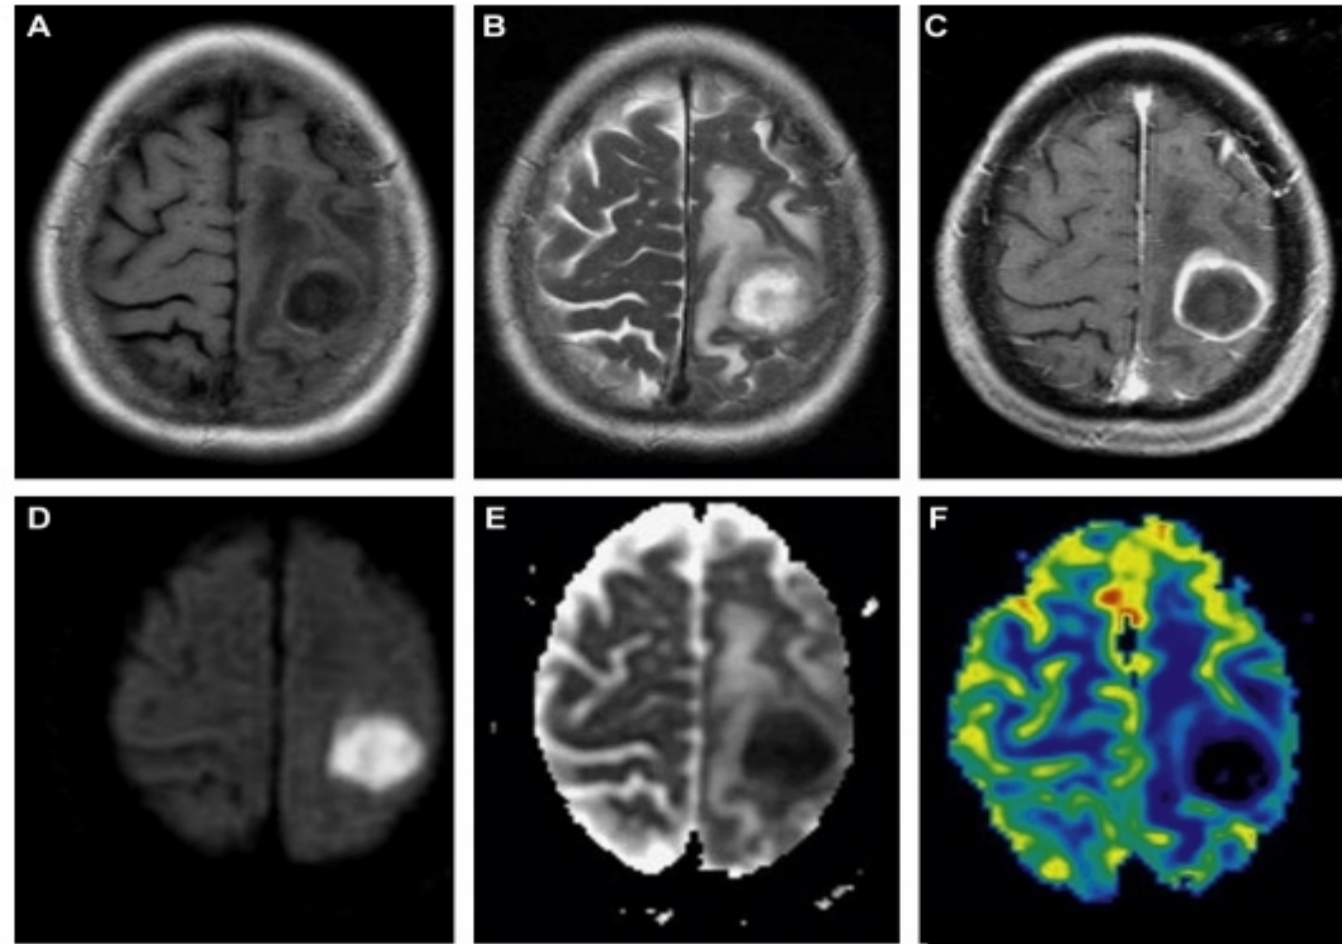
A–F: supratentorial pyogenic abscess in the gray-white junction: T1-weighted (A), T2-weighted (B), gadolinium-enhanced T1-weighted (Gd-MR) (C), DWI ($b = 1000$) (D), ADC (E) and PWI map of CBV (F) MR images. The capsule of the abscess is hyperintense in T1-weighted image (A), partially hypointense in T2-weighted image (B) with surrounding vasogenic oedema. Gd-MR image shows a ring-enhancing mass. The central component of the lesion shows high signal intensity in DWI image (D), and hypointense signal in ADC map, findings that are consistent with restricted diffusion ($ADC = 0.440 \times 10^{-3} \text{ mm}^2/\text{s}$). At PWI, the CBV map (F) does not show evidence of increased perfusion in the gadolinium-enhancing rim ($rCBV = 0.85$).
